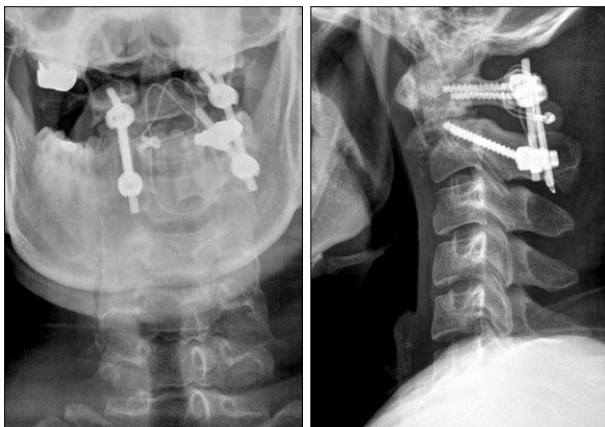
Follow-up radiographics on 6 months postoperatively shows good atlantoaxial stabilization.
